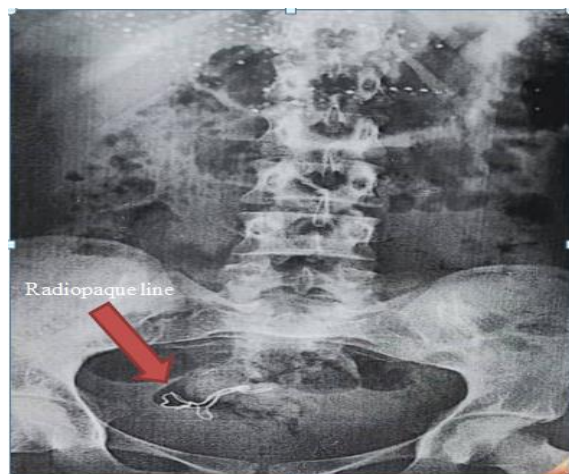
X-ray of the patient's pelvis
